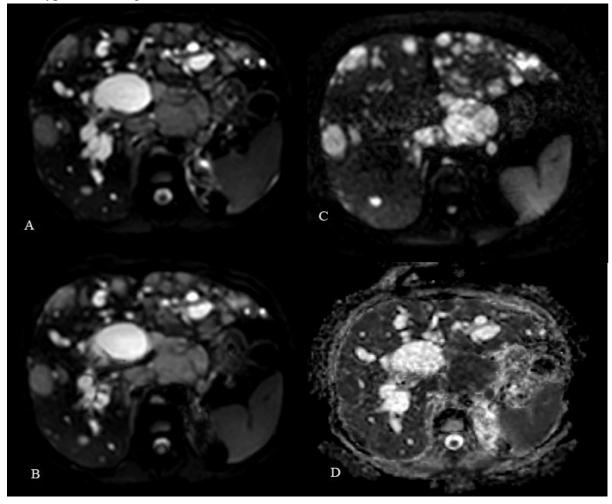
Mutiple focal hepatic lesions becoming more hyperintense on b 1000 DWI image (3C) and showing restricted diffusion (3D), on biopsy proved to be metastasis.
